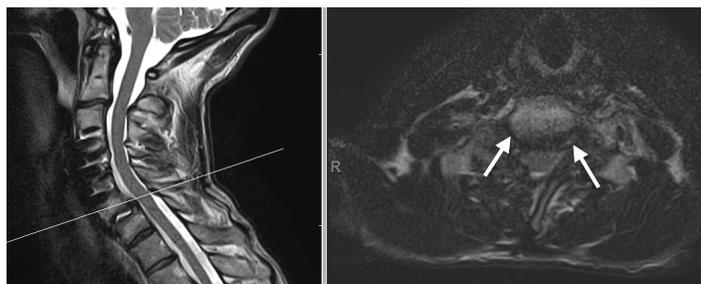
Pre-operative imaging: Cervical MRI shows C7-T1 spondylolisthesis with moderate central canal stenosis, and severe bilateral foraminal stenosis (arrows).
